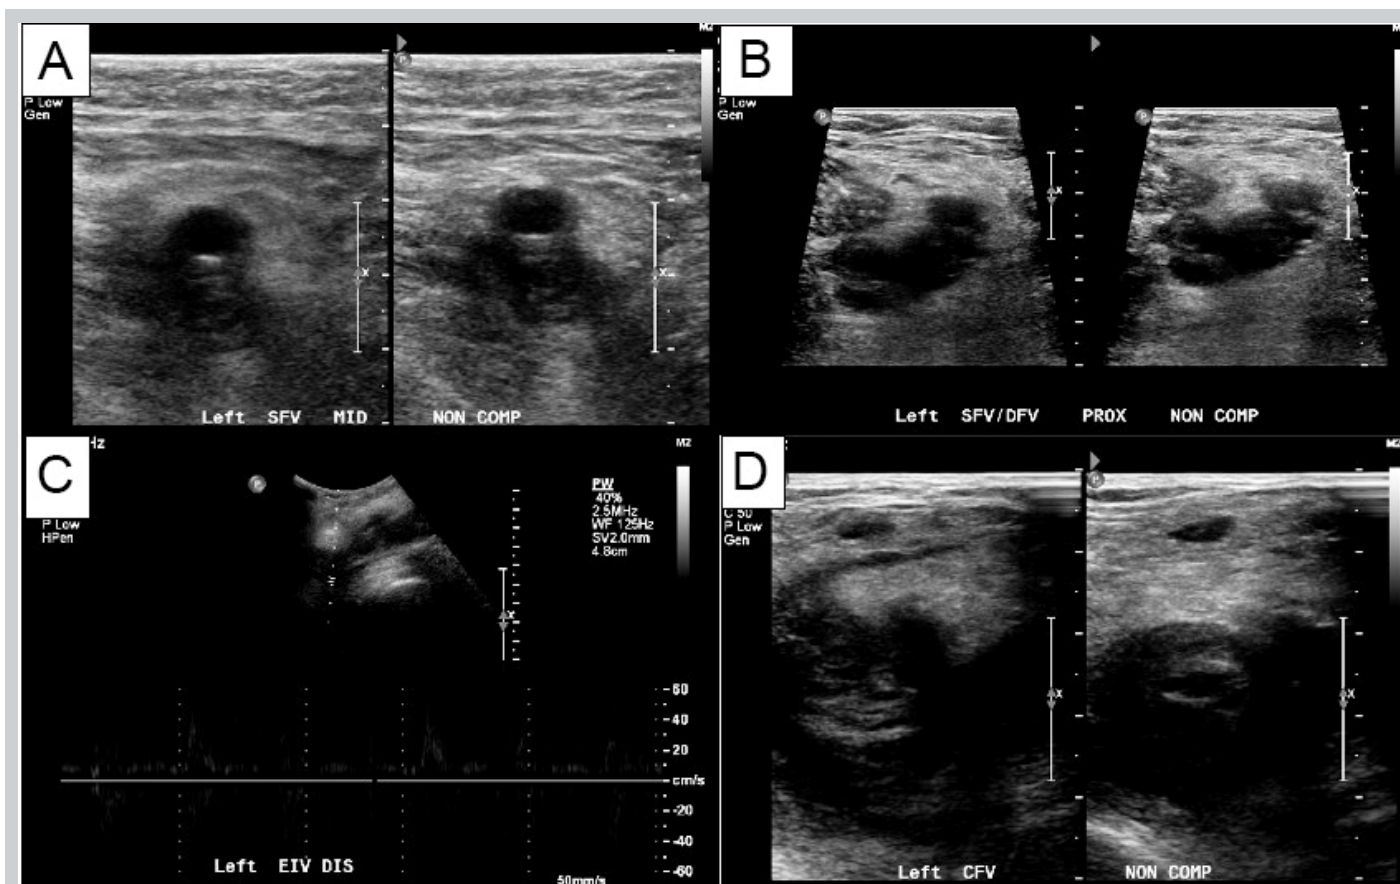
A vascular-performed duplex ultrasound revealed acute non-compressible deep vein thrombosis in the left lower extremity involving (A) the left superficial femoral vein; (B) the left deep femoral vein; (C) the left external iliac vein; (D) the left common femoral vein.
